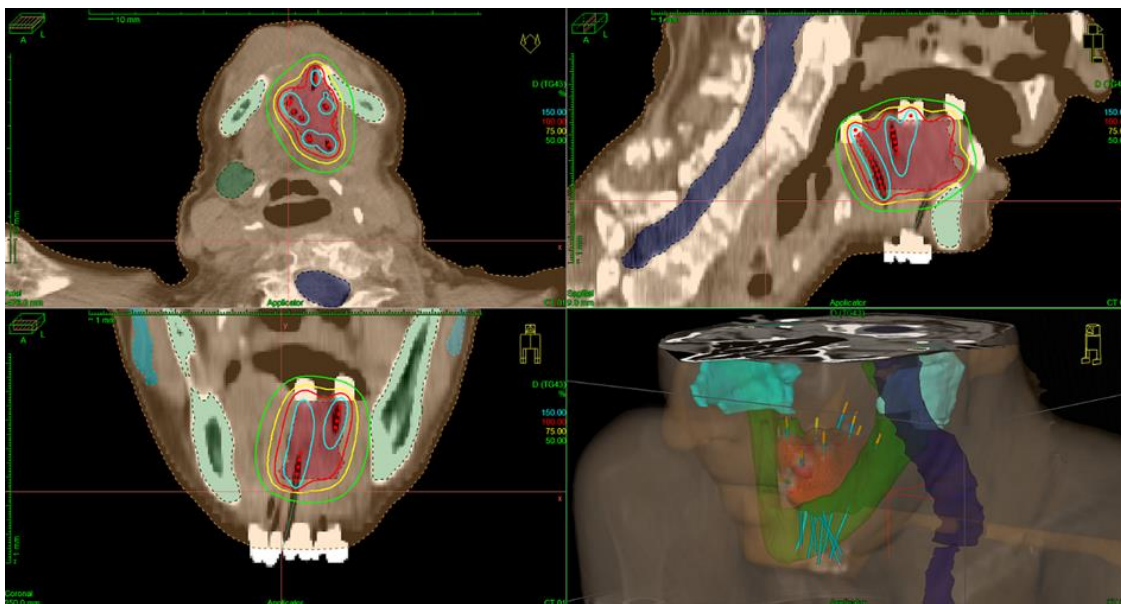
3D-CT reconstruction of the implanted catheters (blue lines) and the calculated dose distribution in relation to PTV (red volume) in axial, coronal and sagittal views (Ferenczi Ö., 2021)
